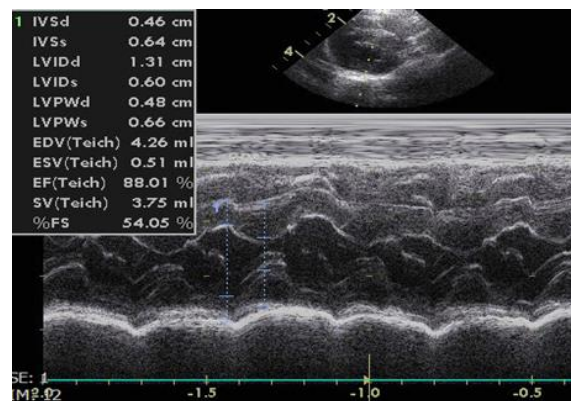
M-mode echocardiographic measurements at the point of left ventricle in right parasternal short axis view.
